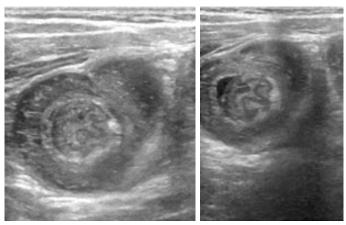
Showing the target sign on ultrasonography
